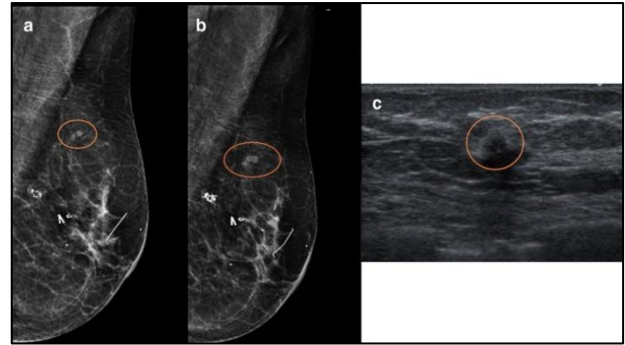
Patient with previous left breast cancer submitted to conservative surgery presented a small circumscribed mass on the left upper outer quadrant at follow-up mammography, mimicking an IMLN (A). Prior exams were not available. At 6-month follow-up, there was an increase in the mass (B), which corresponded to an irregular hypoechoic mass at ultrasound (C) and was confirmed as a recurrent invasive carcinoma after biopsy. IMLN, intramammary lymph nodes.
